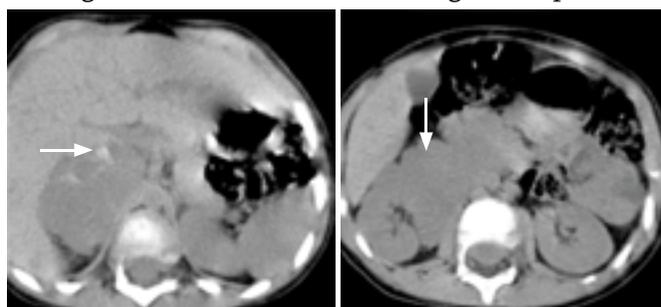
Axial abdominal CT scan without contrast revealing calcified soft tissue mass over the right kidney in the region of the right adrenal gland which was proved to be neuroblastoma after surgery.
